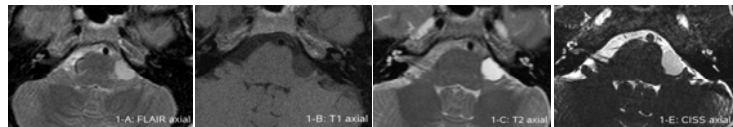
Approximately 1.2 x 0.9 cm extra-axial cystic lesion in the left pontocerebellar angle. Distinctly hyperintense signal compared to CSF and brain tissue in the FLAIR (A, axial) and in T2WI (C, axial), slightly hyperintense to CSF in T1WI (B, axial). In the CISS sequence (E, axial) in comparison to CSF slightly hypointense, but still hyperintense signal compared to the surrounding brain tissue.
